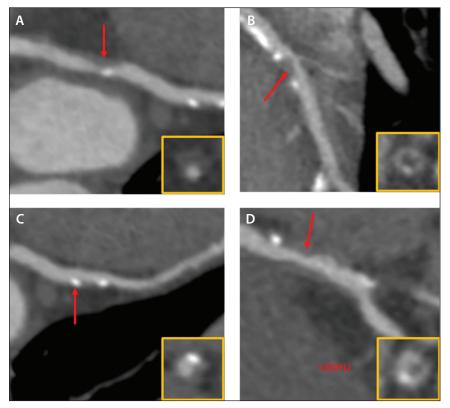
Coronary atherosclerotic vulnerable plaque features as seen on coronary CTA. Positive remodeling (A), napkin-ring sign (B), spotty calcification (C), and low-attenuation plaque (D).
